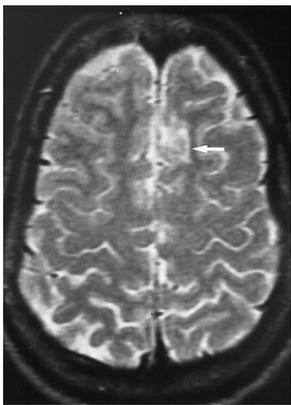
Cortical thickening associated with balloon cell FCDT. Coronal spoiled gradient-echo (25/5/2, 45° flip angle) (A) and T2-weighted (2433/80/1) (B) images show marked cortical thickening in the left frontal lobe. Owing to the coronal imaging plane, a region of increased signal (arrow in B) appears to be surrounded by thickened gray matter. However, the axial T2-weighted (2016/80/1) image (C) shows that this region of increased signal is not in the gray matter but represents a portion of hyperintense subcortical white matter. There is no abnormal enhancement on an axial contrast-enhanced T1-weighted (600/26/1) image (D).
